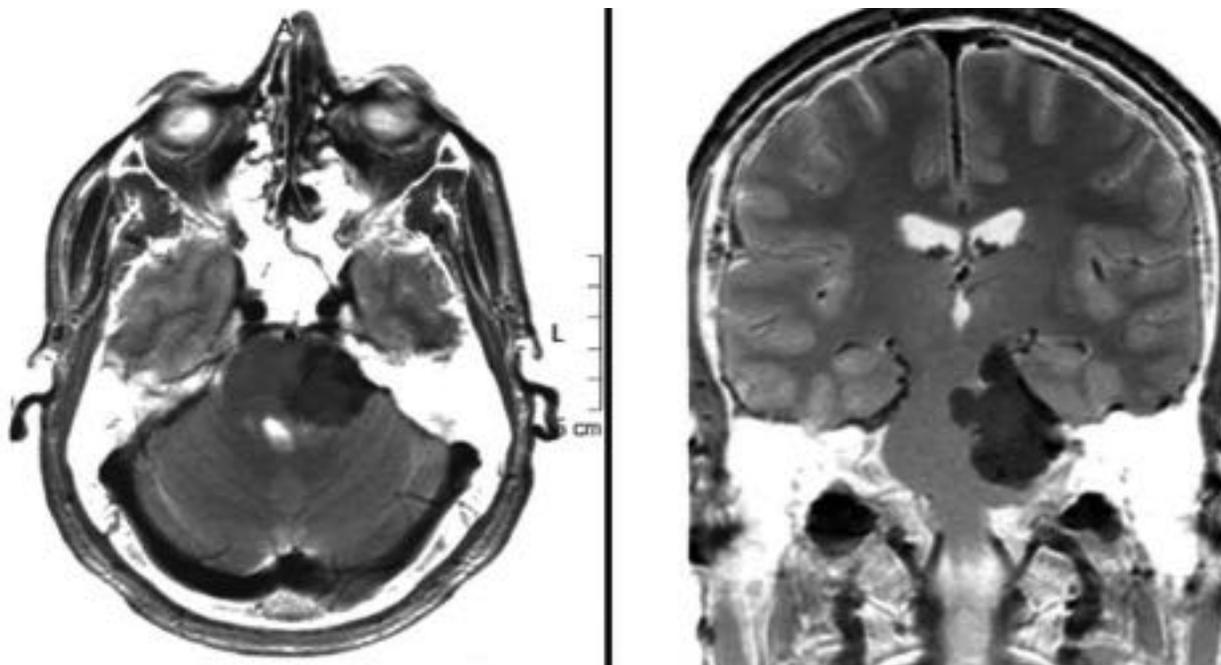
(A) Axial and (B) coronal T1-weighted magnetic resonance imaging after gadolinium injection demonstrating a homogeneously enhancing petroclival and tentorial meningioma.
